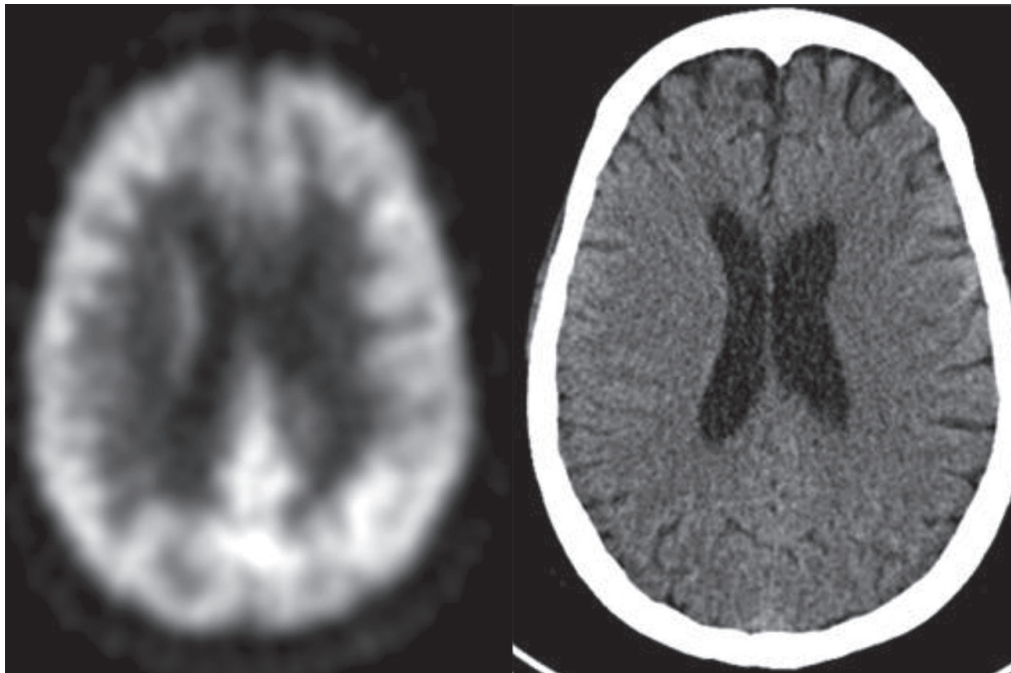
A 43-year-old woman involved in a motor vehicle accident 2 years earlier presenting with headaches, diplopia, poor balance, and memory impairment. CT (*right*) reveals subtle loss of frontal volume. PET (*left*) reveals mild, patchy frontal cortical hypometabolism with moderate decrements in right polar and medial frontal cortex. Patchy, irregular white matter hypometabolism is also seen.
